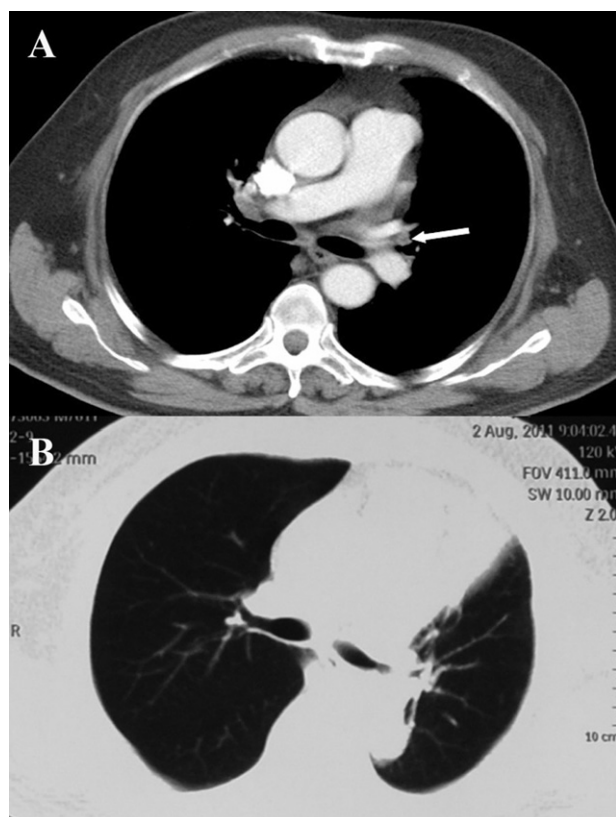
(a) Computed tomography scan showed a small nodule (arrow) of left hilum before surgery. (b) Proper re-expansion of left residual lung at three month follow up.
